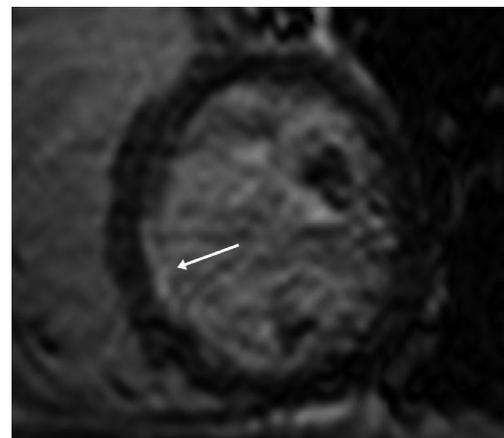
Follow-up cardiac magnetic resonance imaging. Remaining subendocardial enhancement (arrow) is still observed in the interventricular septum of the LV in the delayed contrast-enhanced CMR of the LV, but the extent of enhancement is decreased.
